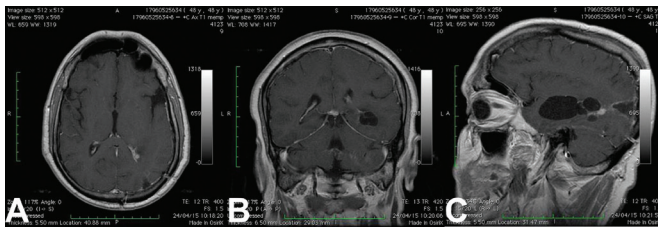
Postoperative (A) axial, (B) coronal and (C) sagittal sections of T1-weighted MRI of the patient confirmed the removal of the tumor.
